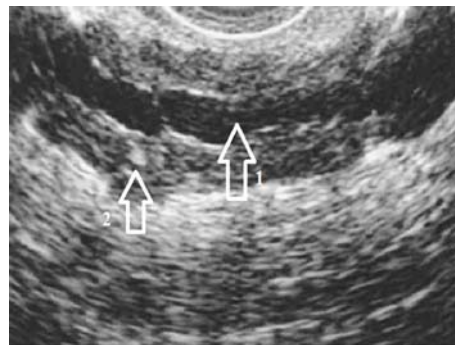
Endoscopic ultrasound scan: duct dilatations (arrow 1) and calculi (arrow 2)
